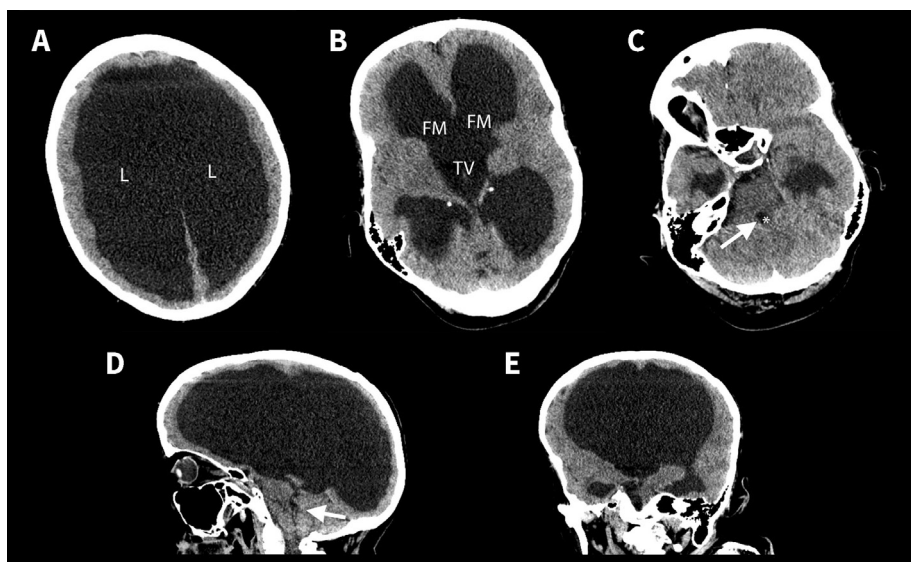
Computed tomography images showing massive ventriculomegaly in the brain of a 72-year-old woman. Axial views at the level of (A) the lateral ventricles showing thinned cortex, (B) the foramen of Monro showing an open foramen of Monro and enlarged third ventricle, and (C) the fourth ventricle showing the small caliber of the fourth ventricle (arrow). (D) Sagittal (arrow indicates the fourth ventricle) and (E) axial views showing obstructive ventriculomegaly. Note: L = lateral ventricle, FM = foramen of Monro, TV = third ventricle.
